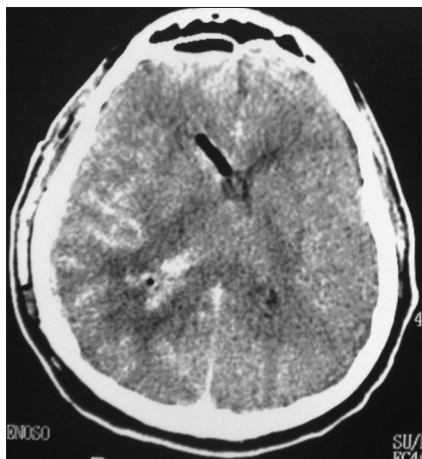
Postoperative image, brain computed tomography scan (with contrast)
